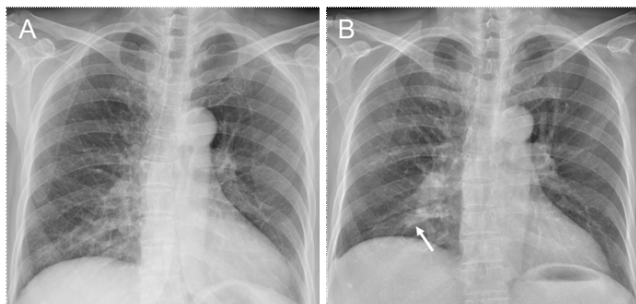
Chest X-rays. (A) negative; (B) pulmonary tumor thromboembolism (arrow).
